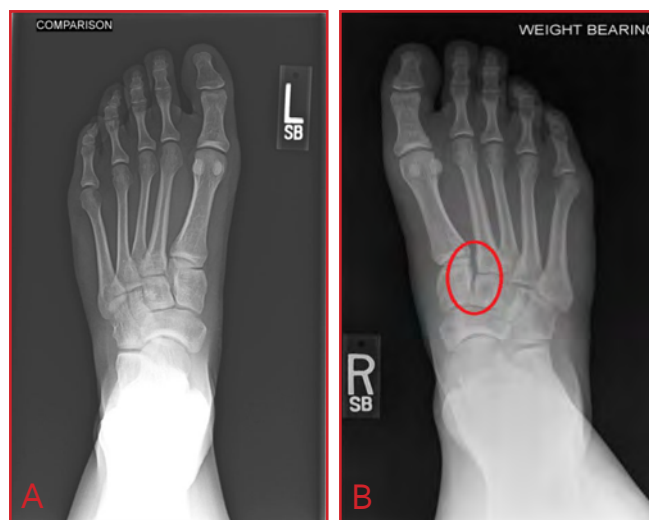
Radiographs of the (A) uninjured left foot and (B) injured right foot, showing slight widening at the Lisfranc joint (circled).
